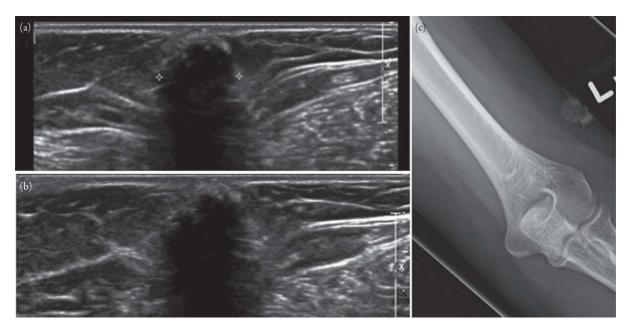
Soft tissue calcified mass. Panels (a) and (b), respectively, show grayscale sonographic images in longitudinal plane of a heavily calcified solid soft tissue mass with extensive posterior acoustic shadowing. A companion plain radiograph demonstrates a partially calcified soft tissue mass (Panel (c)).
